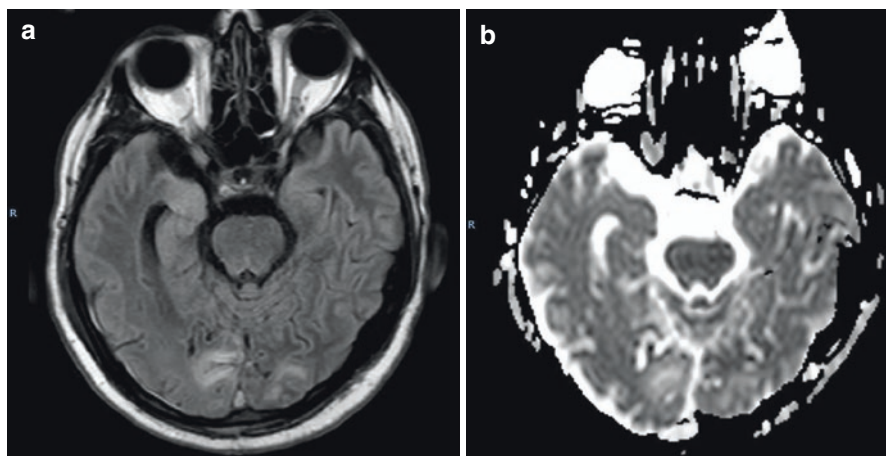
T2 weighted (a) and diffusion weighted (b) axial MRI scan showing infarction of the right occipital lobe and posterior temporal (fusiform) gyrus
